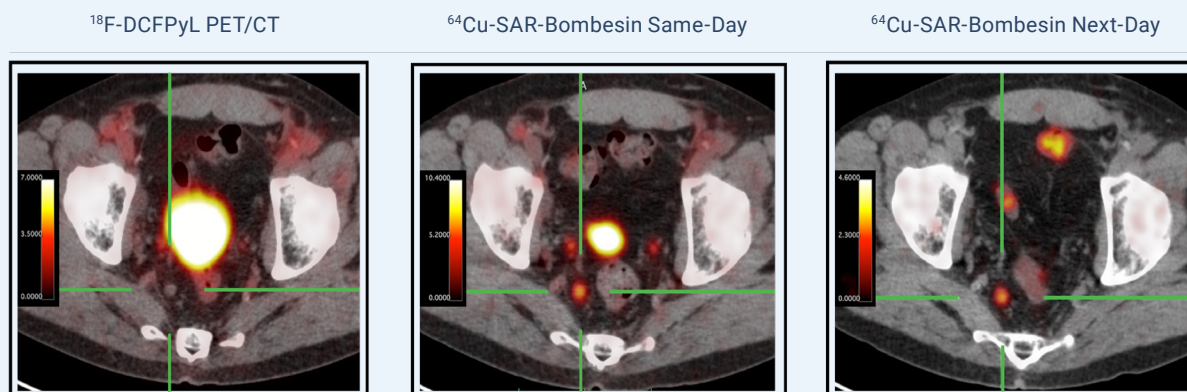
^{64}Cu SAR-Bombesin detected a positive lymph node on scans performed on 2 different days (same-day and next-day scans). No uptake was observed using ^{18}F -DCFPyL (Pylarify®) PET/CT. A subsequent biopsy, performed and assessed locally by the study site, has confirmed prostate cancer.
